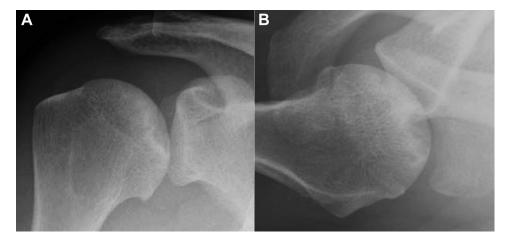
The initial finding of the plain radiograph. A subchondral lucency with a sclerotic rim and mild inferior osteophyte formation were noted in the humeral head. (A) Anterior-posterior view of the right shoulder. (B) Axillary view of the right shoulder.
